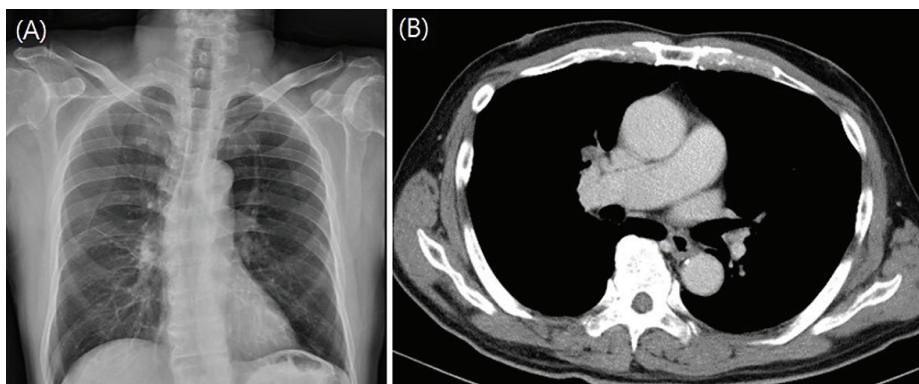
Follow-up chest radiograph (A), and chest CT (B), following a 6-month amoxicillin-clavulanate treatment course revealed resolution of the right hilar mass.
